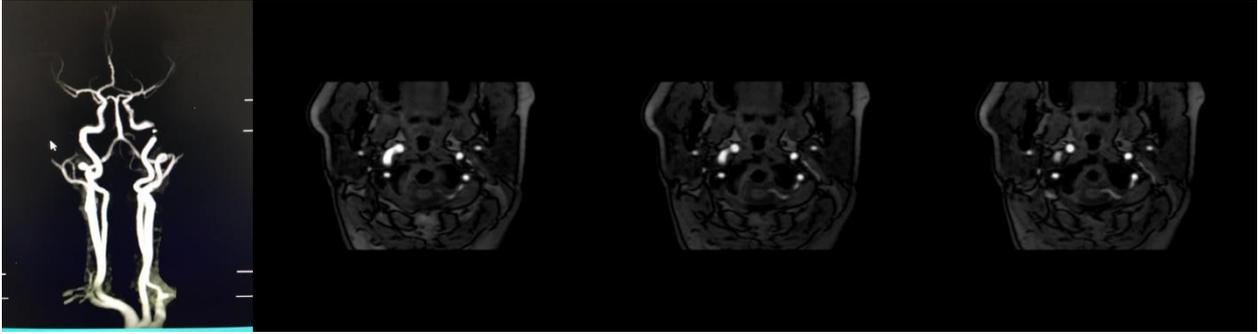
MRI angiogram neck showed anomalous origin of left posterior inferior cerebellar artery (PICA) at C1-C2 level and intradural entry from left side at C1-2 interlaminar space.
